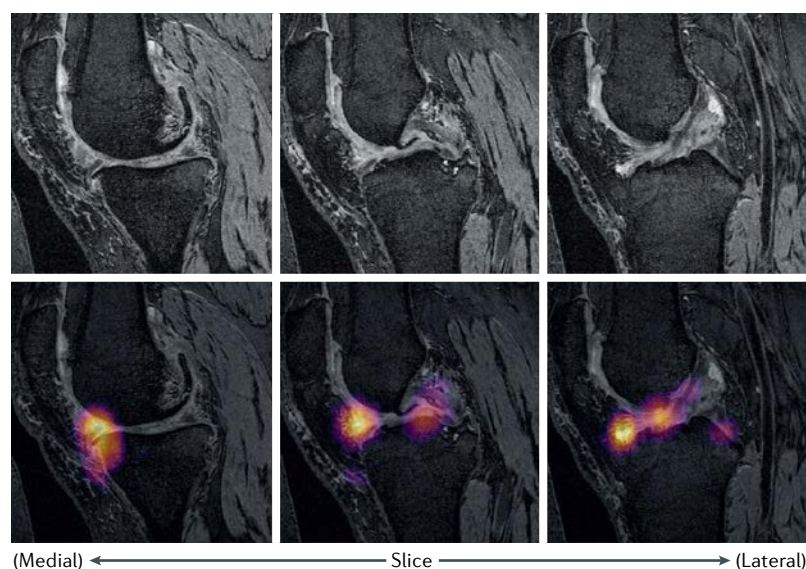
Anatomical structures on MRI scans influencing artificial intelligence model prediction of total knee replacement within 5 years. MRI slices (top row) and corresponding occlusion map slices (bottom row) of a knee classified by artificial intelligence as a true positive for undergoing future total knee replacement (TKR) within 5 years of initial MRI assessment¹¹⁶. Hotspots in occlusion maps for 124 true-positive knees were used to anatomically identify tissue types that corresponded with undergoing TKR within 5 years. Compared with true-negative controls, knees with hotspots in the medial patellar retinaculum, gastrocnemius tendon and plantaris muscle predicted higher odds of undergoing TKR, whereas hotspots in the medial and lateral tibiofemoral joint, meniscus and anterior cruciate ligament portended decreased odds of undergoing TKR. A hotspot refers to a portion of the image that the model assigns a weight to for decision-making, but it is not known how that portion of the image directly affects the final prediction owing to the ‘black box’ nature of artificial intelligence algorithms. Identifying model hotspots only informs the reader that the model is utilizing specific regions in different ways from other knee structures for its final decision. For example, the negative odds of needing TKR for the anterior cruciate ligament hotspot only denotes that this pixel location is used in determining the presence or absence of future TKR, but it is not known in which of the two directions it contributes to this prediction. Reprinted from REF.¹¹⁶, CC BY 4.0 (<https://creativecommons.org/licenses/by/4.0/>).
